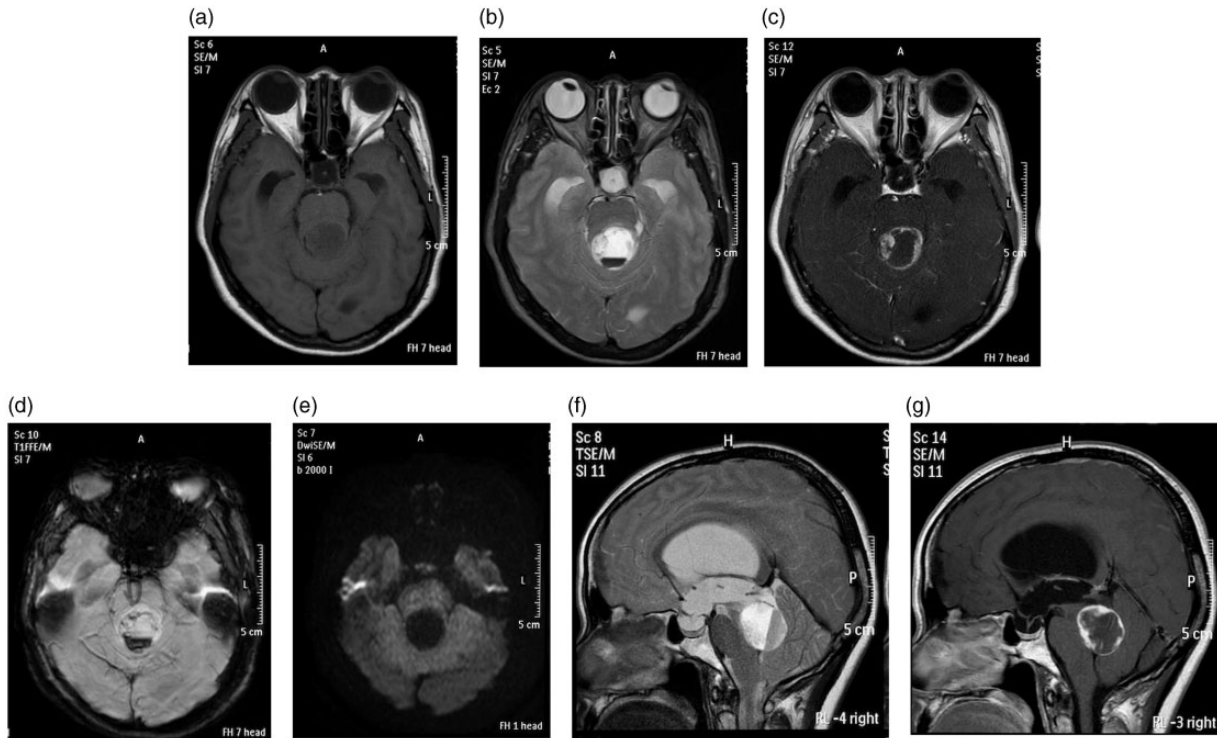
(a and b) MRI study shows a T1-weighted hypointense, T2-weighted hyperintense intraventricular lesion in the fourth ventricle, complicated by moderate obstructive hydrocephalus. (c and g) Ring enhancement and mural nodules are seen. (d and f) Intralesional fluid–fluid level with susceptibility artifacts indicates tumor hemorrhage. (e) No restricted diffusion is demonstrated.
